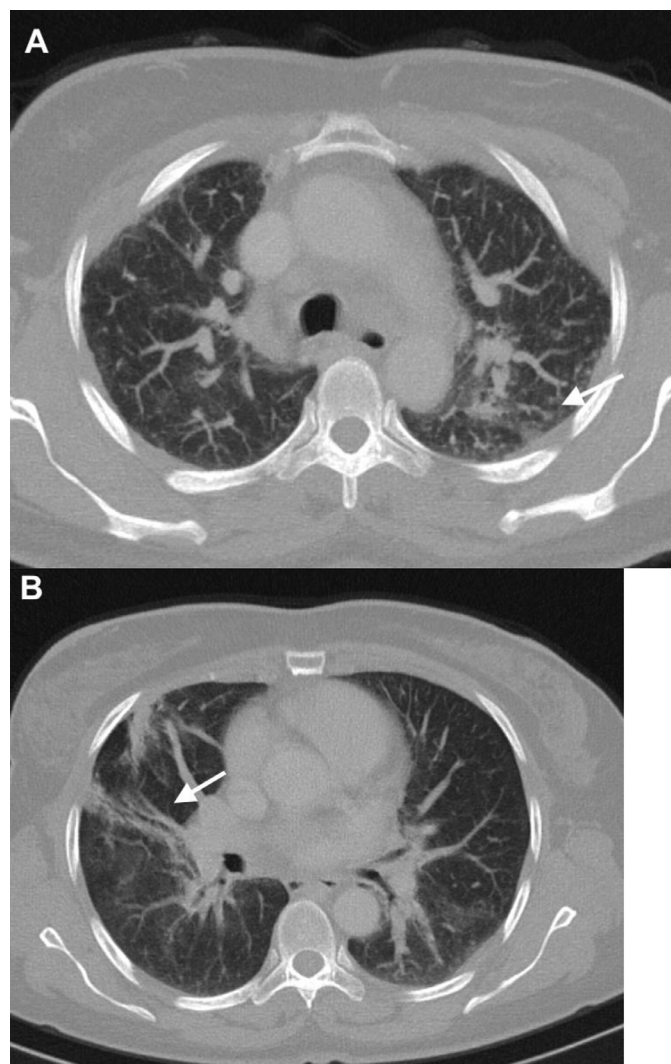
Thoracic CT in axial section, in lung window, demonstrating perilymphatic distribution of micronodules (A) along with peribronchovascular thickening and pulmonary architectural distortion (B).
